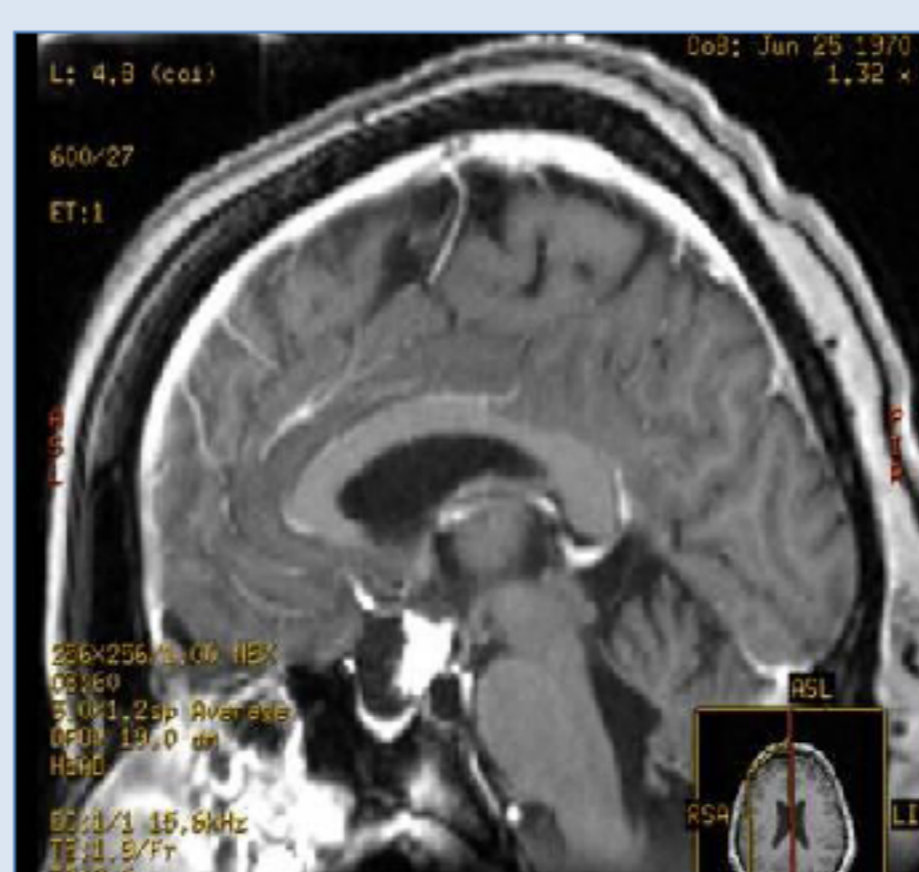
Cranial MRI before the second surgery
